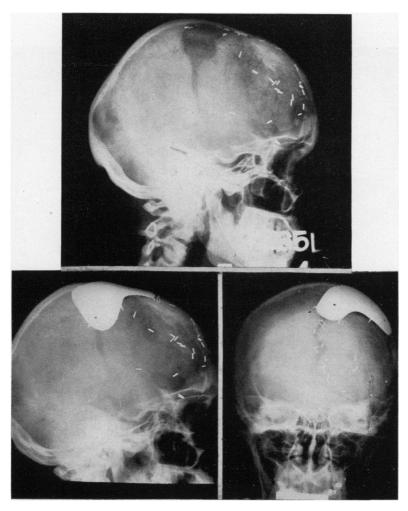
Case 4: Roentgenograms of skull defect following craniotomy for tumor and subsequent tantalum cranioplasty and wire fixation of remaining bone plate.
